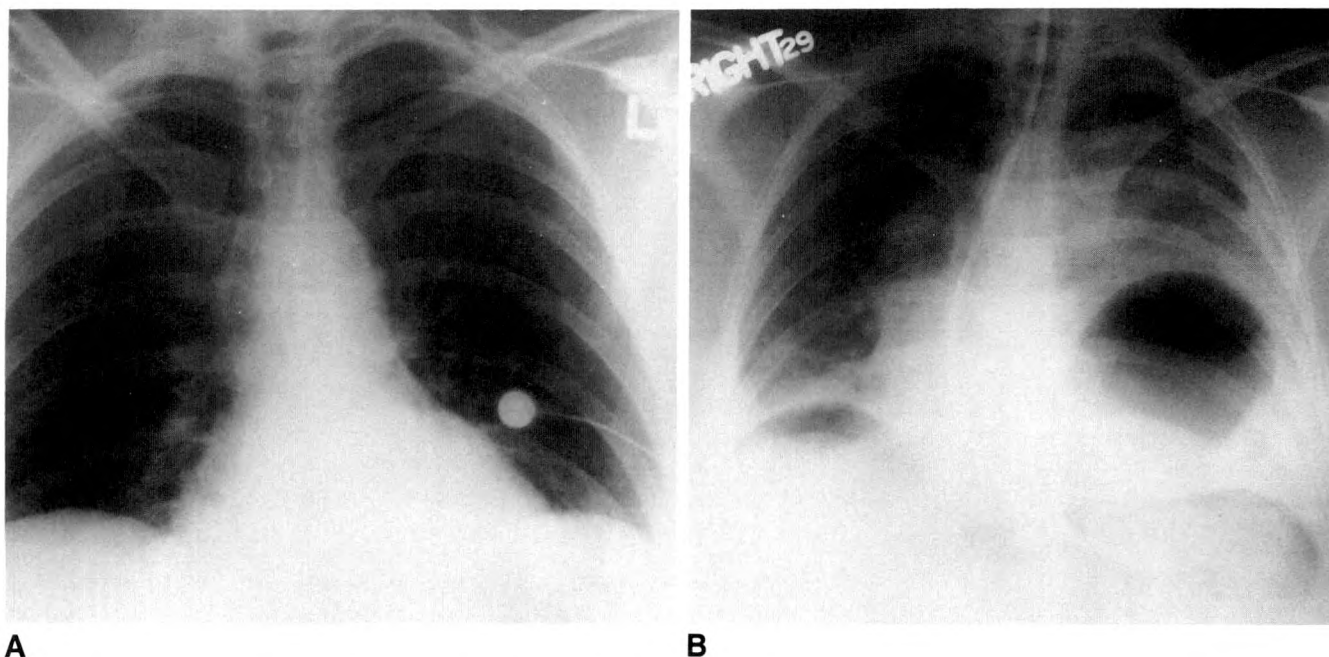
A, Chest radiograph shows normal contour and position of left hemidiaphragm. B, Chest radiograph obtained 2.5 hr after initial radiograph (A) shows loss of left hemidiaphragm contour, a large gas collection at left lung base, and a left pleural effusion. Mediastinum is shifted to right. A pneumoperitoneum has developed in interim. Surgery revealed an 8-cm rupture of left hemidiaphragm with herniation of gastric fundus into left hemithorax.
